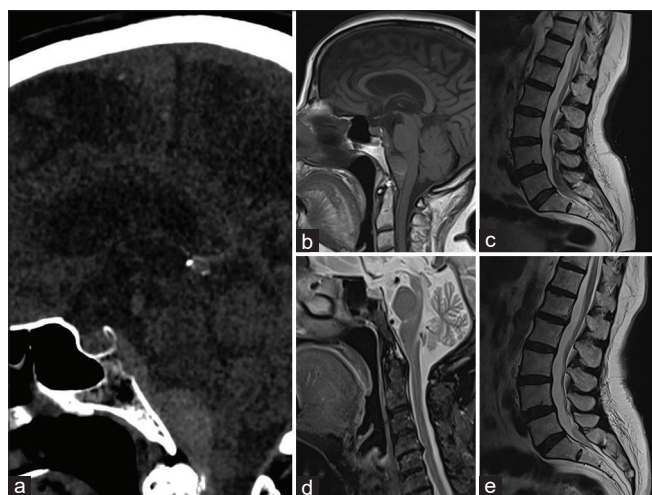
(a) Sagittal cranial computed tomography image at admission demonstrates a hyperdense mass posterior to the clivus. (b) Sagittal craniocervical T1-weighted magnetic resonance image shows a retroclival epidural hematoma extending inferiorly. (c) Sagittal lumbar spinal T2-weighted magnetic resonance image shows an epidural hematoma. (d and e) Follow-up magnetic resonance images 3 weeks after discharge show hematoma regression
